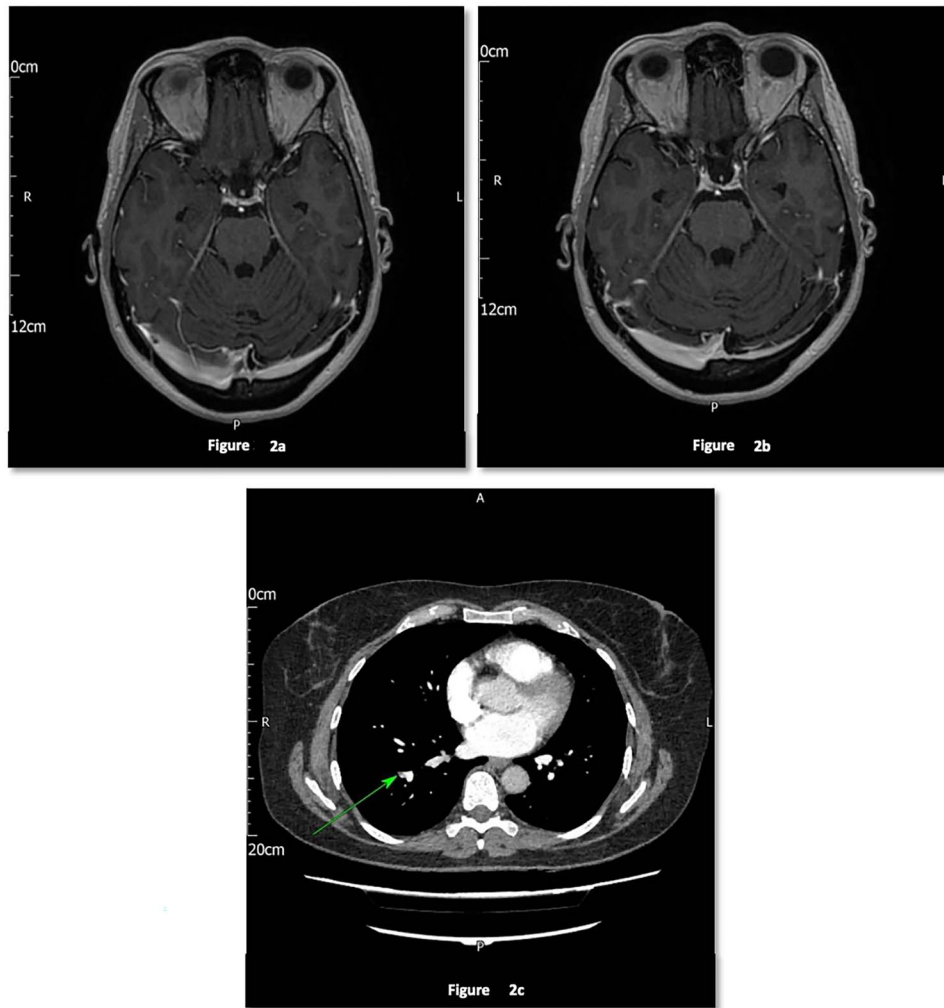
(a) MRI—dominant right transverse sinus, (b) MRI—filling defect in right transverse sinus and (c) CTPA showing subsegmental filling defects.
